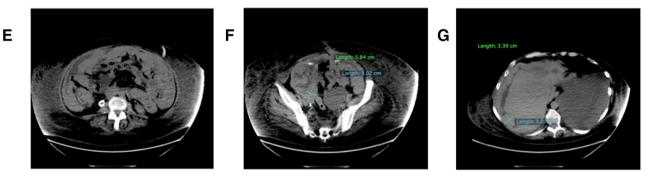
CT Images and comparative analysis of ChemoID test results on Bulk of Tumor and Cancer StemCells of a patient affected by third recurrence of an ovarian cancer. A) Baseline CT images show presence of large amount of ascites in December of 2016, with B) ovarian mass measuring 9.3×5.4 cm, and C) peritoneal carcinomatosis measuring 3.5×5.1 cm. D) Comparative ChemoID analysis on Bulk of Tumor and Cancer Stem Cells obtained from fresh ascites aspirate. E) Control CT images in November of 2017 following a Doxorubicin regimen showing regression of ascites, F) smaller ovarian mass measuring 5.8×3 cm, and G) smaller peritoneal carcinomatosis measuring 3.4×3 cm.
